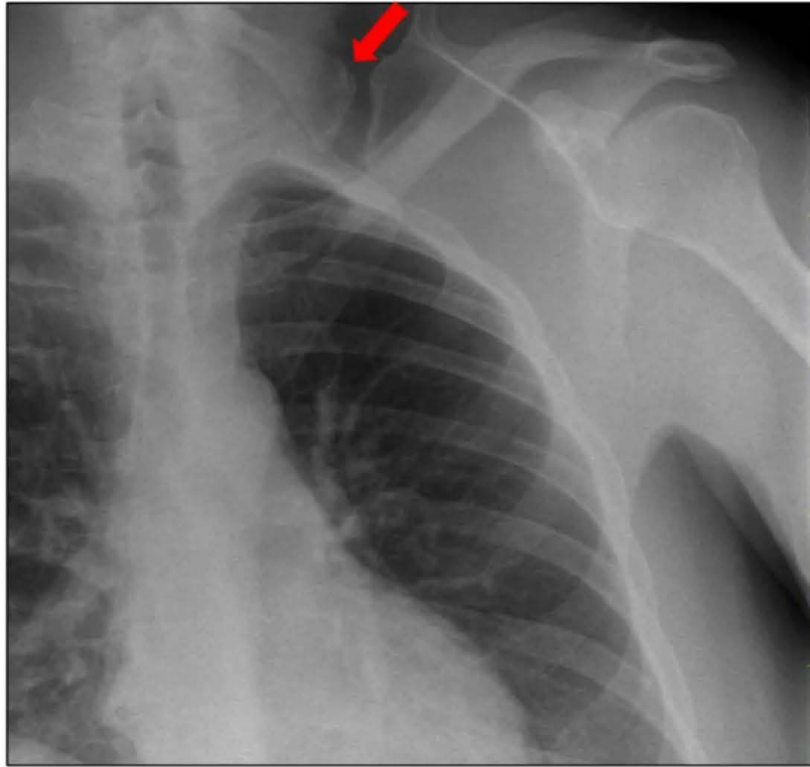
Cropped PA chest x-ray showing the deformity (arrow marking omovertebral bone)
